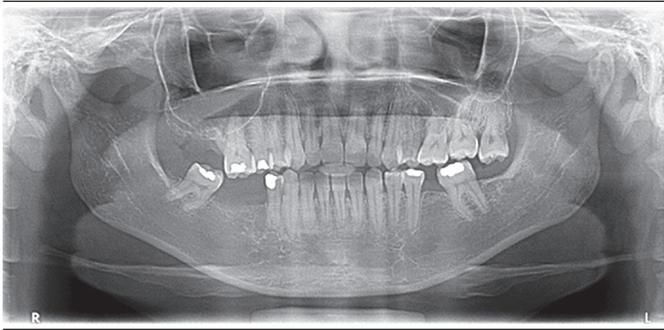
Panoramic radiograph with absence of radiographic changes in the region of the lesion
